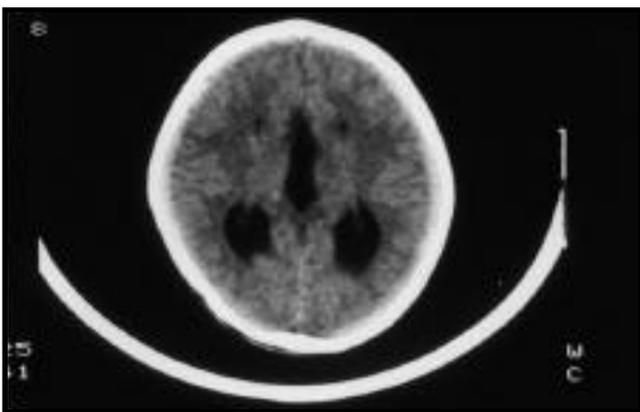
Cranial CT scan showing elevation of dilated third ventricle.
